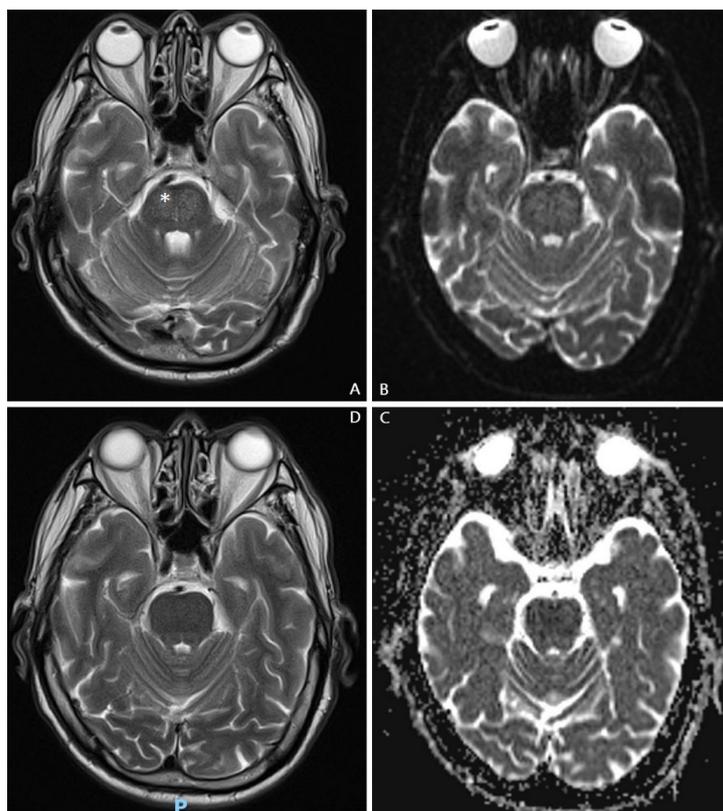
MRI scans of the patient's brain showing (A) T2-weighted signal hyper-intensity in the central pons suggestive of CPM; (B) similar increased signal shown in diffusion-weighted imaging (DWI); (C) signal iso-intensity on apparent diffusion coefficient (ADC) mapping which ruled out an infarct; (D) comparison with the patient's previous MRI findings a year before, showing normal T2-weighted signal, when he presented for a separate neurological complaint (TIA); * represents the lesion of interest.
